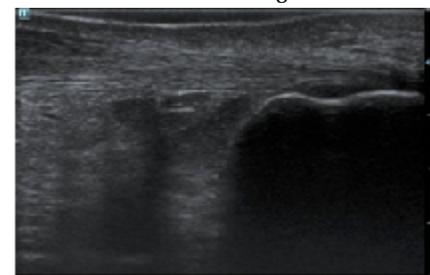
Ultrasound longitudinal view at baseline of the Achilles tendon showing tendinopathy alterations: arrows show the modified region
